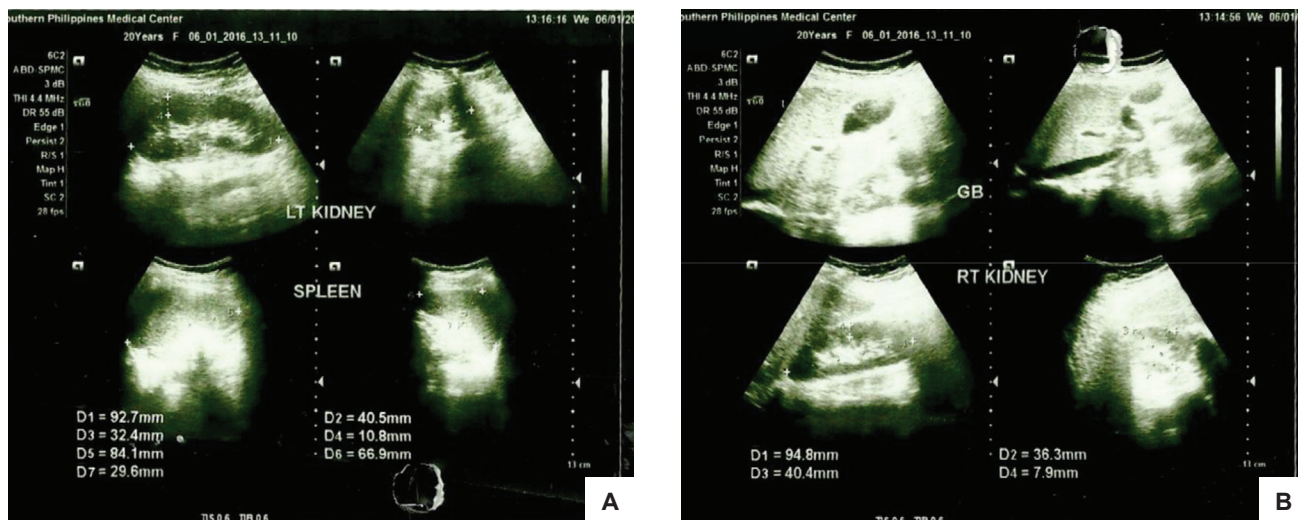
Ultrasound of the abdomen revealed presence of normal left (A) and right (B) kidneys.
